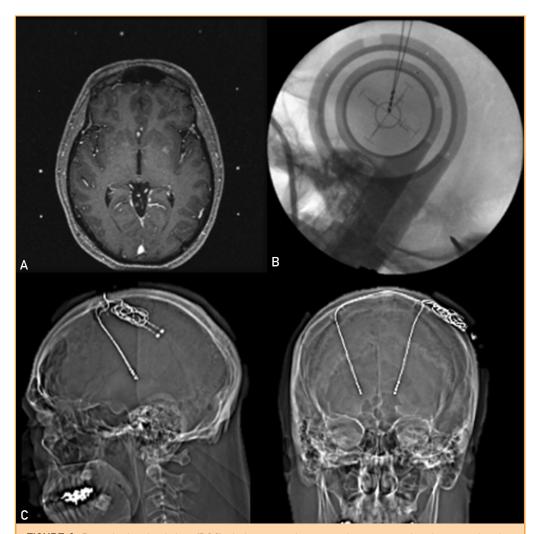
Deep brain stimulation (DBS). A, Intraoperative magnetic resonance imaging scan showing magnetic resonance fiducial markers that are used for stereotactic planning of the ventrolateral intermedius (VIM) thalamus for the treatment of essential tremor. B, Intraoperative fluoroscopy scan showing the accurate placement of bilateral VIM thalamic DBS leads. C, Postoperative head computed tomography scan showing the accurate placement of bilateral VIM thalamic DBS leads in the sagittal (left) and coronal (right) planes.
